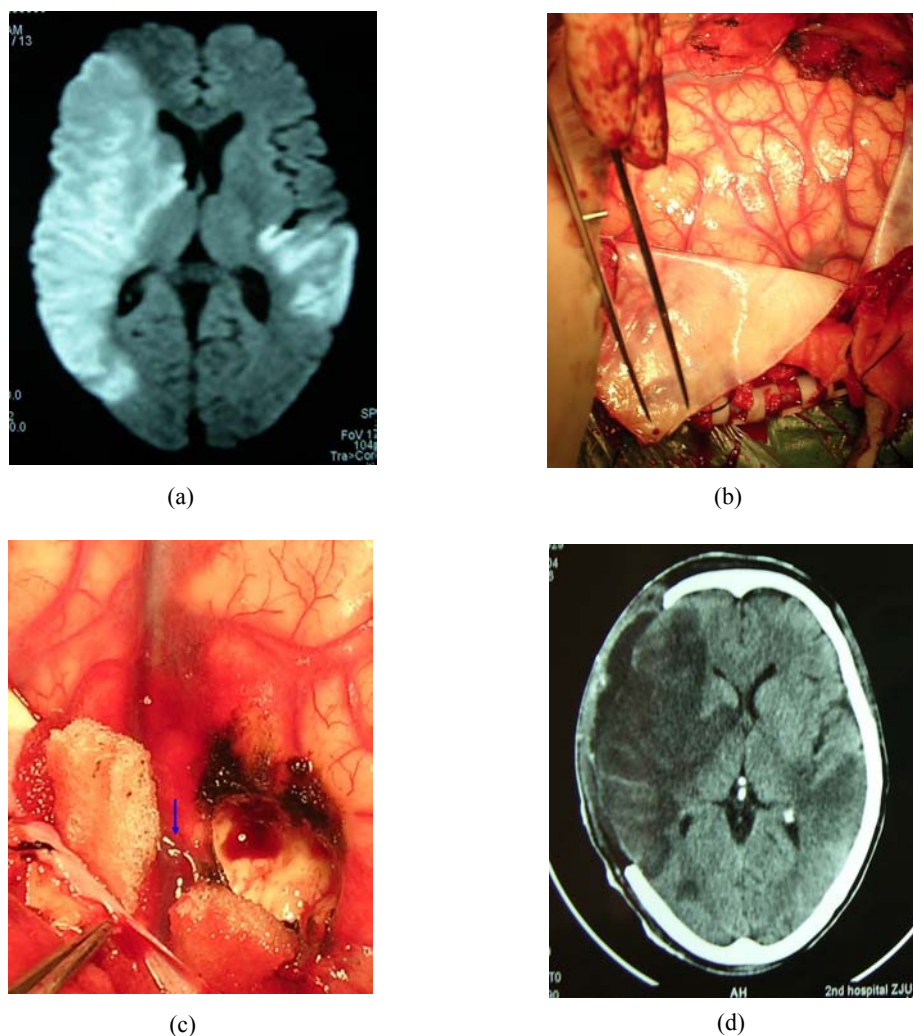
CT and operative images of brain of one patient with sudden onset of left hemiplegia and coma. NIHSS at operation was 27 (a) The diffusion weighted imaging (DWI) showed a large hyperintensity area at right MCA and ACA territory; (b) During decompressive craniectomy, after a star-shaped durotomy, the infarcted tissue bulged out; (c) Intraoperative picture of vascular tunnel (arrow) around the vein at dural margin, also shows excision of necrosis tissue in the base of temporal lobe; (d) Postoperative CT image of large MCA and ACA infarction
